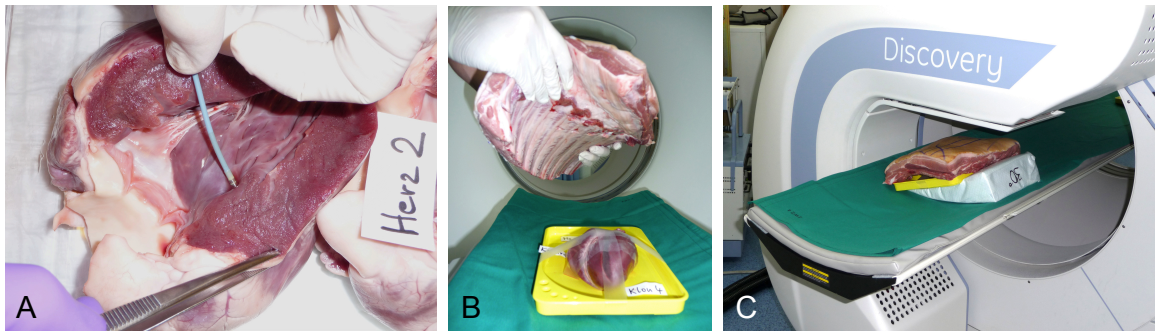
Ex vivo Stammzellapplikation und Nachweis mittels Hybrid-SPECT-CT Imaging
